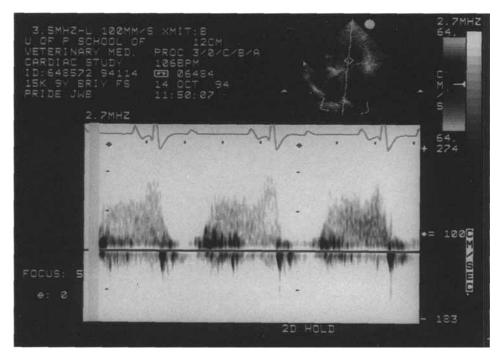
Continuous wave spectral Doppler of left ventricular inflow, from the left apex. The sustained diastolic, positive-velocity, Doppler signal indicates mitral inflow obstruction.
